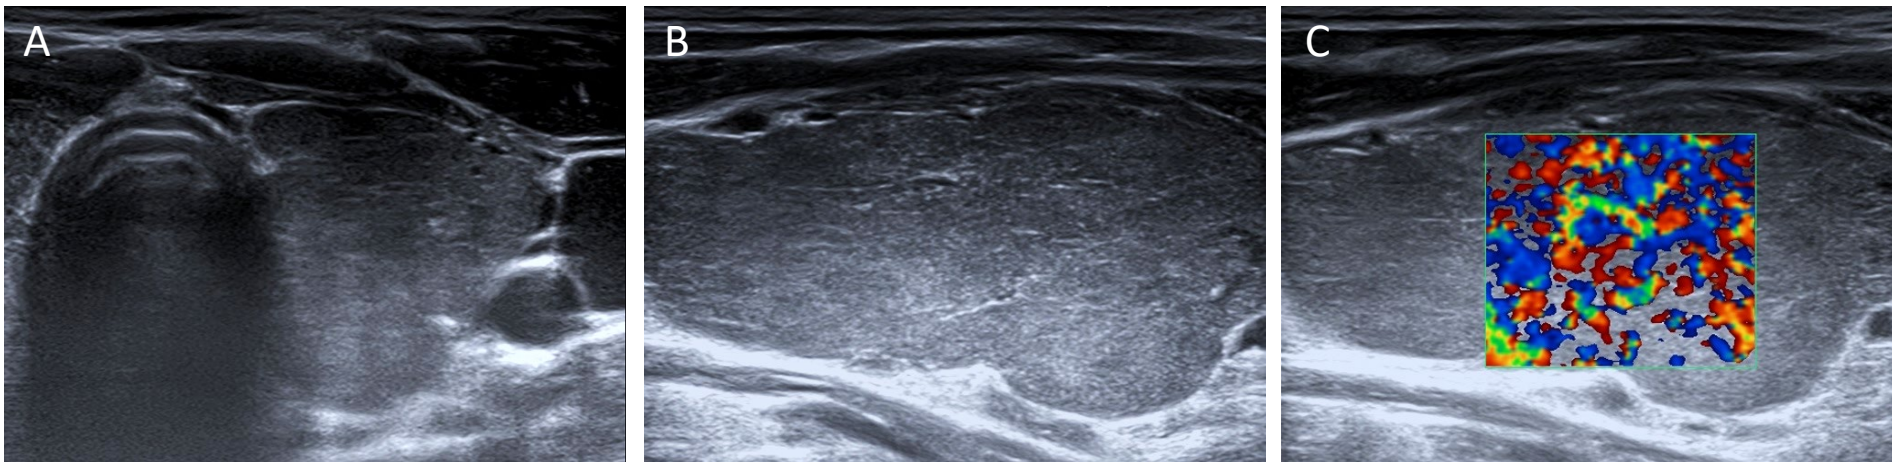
Axial (A) and longitudinal (B) US views showing a lobulated, enlarged left thyroid lobe and diffuse hypoechoogenicity with fine reticulations. C. Power Doppler US demonstrating the typical aspect of a « thyroid inferno » due to diffusely increased parenchymal vascularity.
